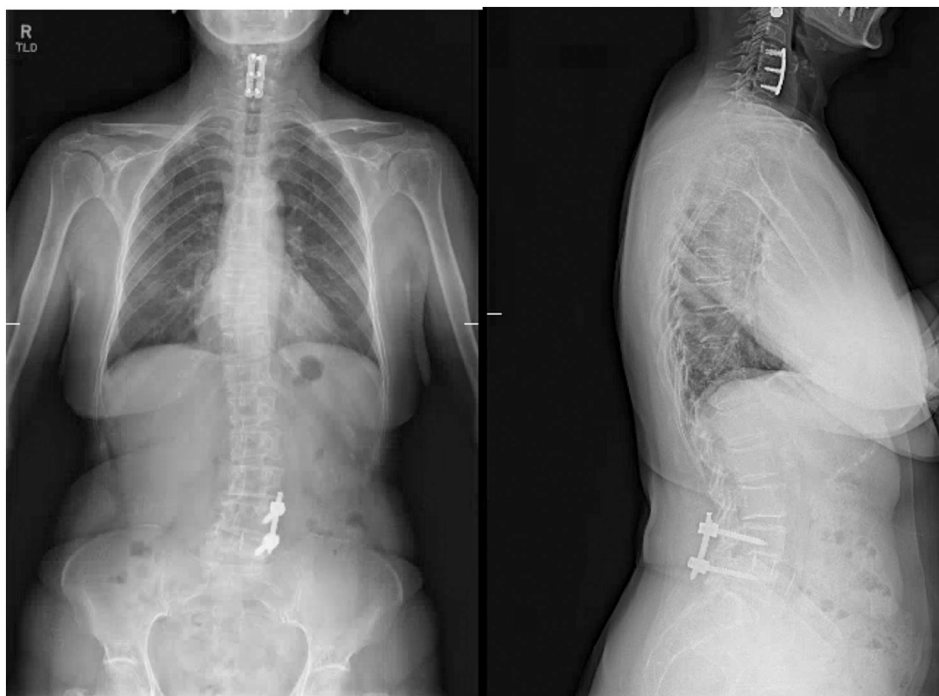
Anteroposterior (left) and lateral (right) scoliosis radiographs demonstrating prior anterior interbody graft at L4/L5, anterolisthesis at L4/L5, and L convex scoliosis, apex L3 with Cobb's angle 16°.
